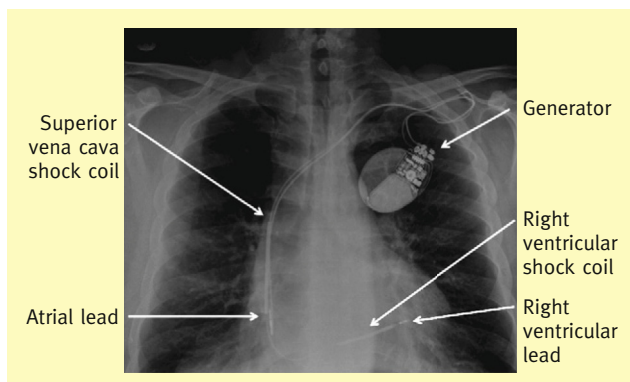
A posteroanterior chest radiograph showing a dual chamber ICD.
